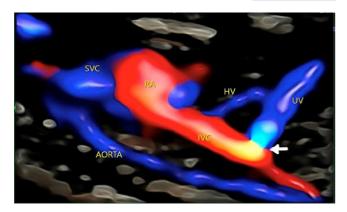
3-dimensional color Doppler acquisition depicting abnormal drainage of umbilical vein (UV) into inferior vena cava (IVC) via presence of a DV-like shunt at the junction (shown by an arrow), SVC- superior vena cava, RA-right atrium, HV-hepatic veins
